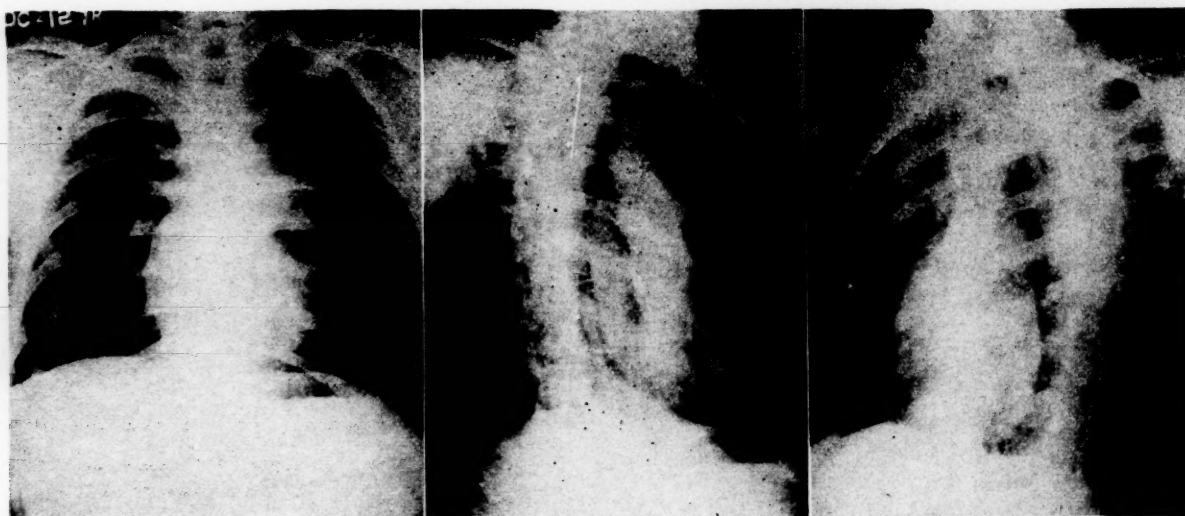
Roentgenogram of the patient's chest in Case II, postero-anterior projection.
